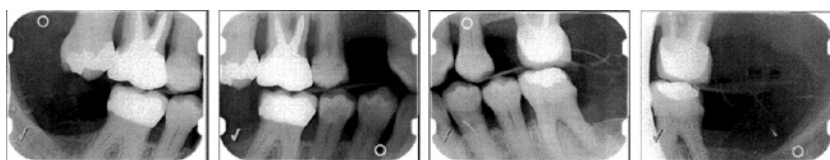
Bitewings before laser treatment.
